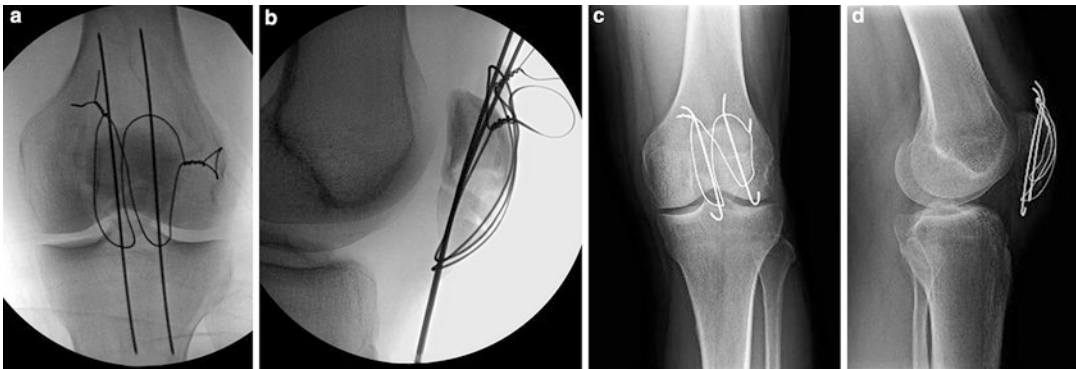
Intra-operative C-arm images of a horizontal figure of eight tension band technique: (a) anteroposterior and (b) lateral. Postoperative radiographs of a healed patella
